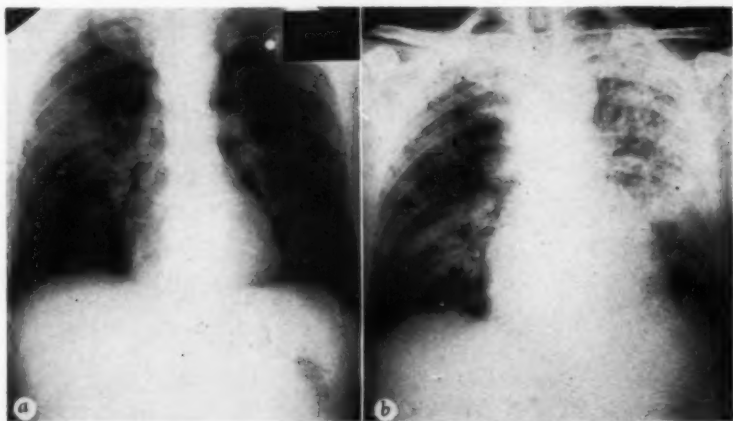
(case 2) a and b: The roentgenograms were taken 14 days apart. The pathologic process has progressed during this time despite the use of ACTH. The second roentgenogram was taken 4 days before death. At necropsy, changes compatible with necrotizing alveolitis were present in both lungs.
